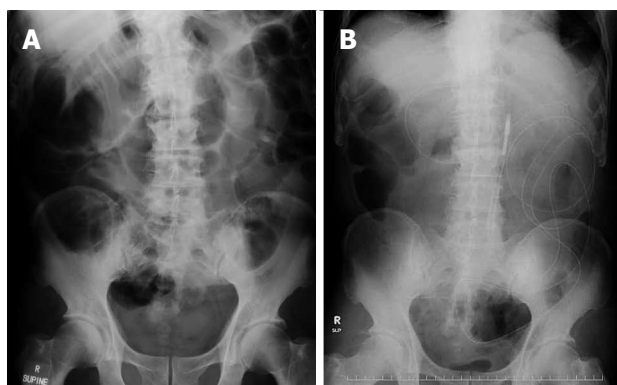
Abdominal X-ray. A: Intestinal obstruction at hospitalization; B: abdominal X-ray after long intestinal intubation.
